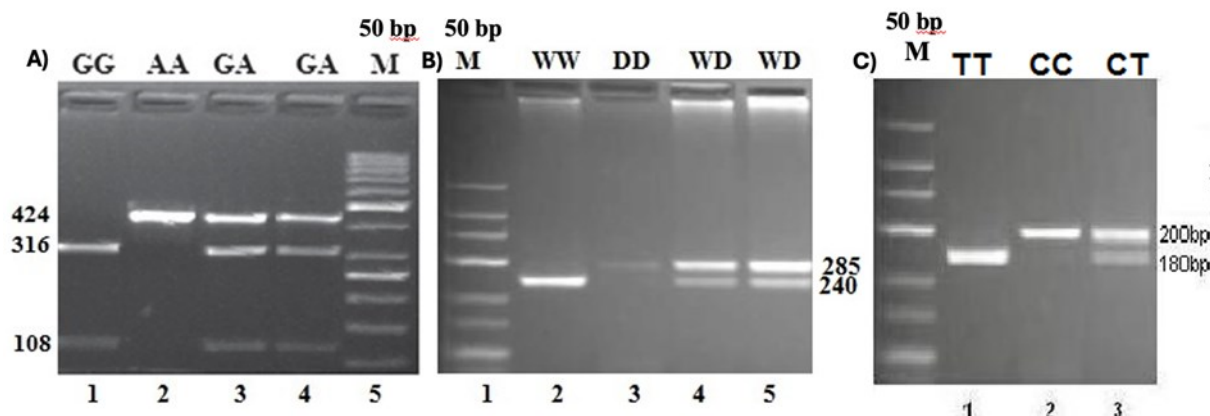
PCR-RFLP and sequence analysis of NF- κ B1 W/D and NF- κ B1A 3'UTR A→G and -826C/T polymorphisms. A) NF- κ B1A 3'UTR A → G polymorphism, AA genotype: 424 bp number 2, GA genotype: 424, 316 and 108 bp; numbers 3 and 4, GG genotype: 316 and 108 bp; number 1. Marker: 50 bp; B) NF- κ B1 -94W/D polymorphism, WW (ins/ins) genotype: 240 and 45 bp; number 2, WD (ins/del) genotype 285, 240 and 45 bp; numbers 4 and 5, DD (del/del) genotype 285 bp; number 3. M: 50 bp; C) NF- κ B1A -826C/T polymorphism genotypes formed after cutting with Bfa I enzyme. Sample number 1 is TT genotype (20 bp + 180 bp). Sample number 2 is the CC genotype (200bp). Sample number 3 CT genotype (20bp+180bp+200bp). Marker: 50 bp.
